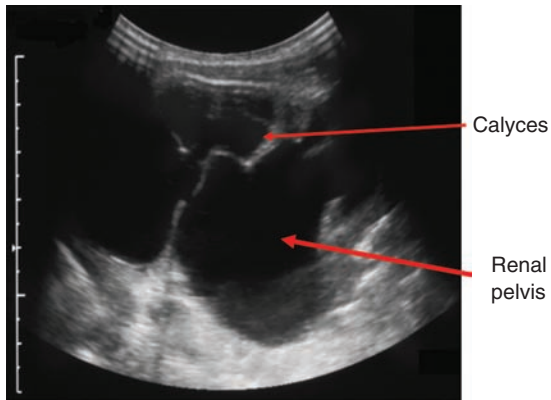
Postnatal ultrasound confirming antenatal ultrasound appearances of grossly hydronephrotic (dilated) right kidney with marked dilatation of renal pelvis and calyces with thinned cortex (renal pelvic AP diameter = 32 mm).
